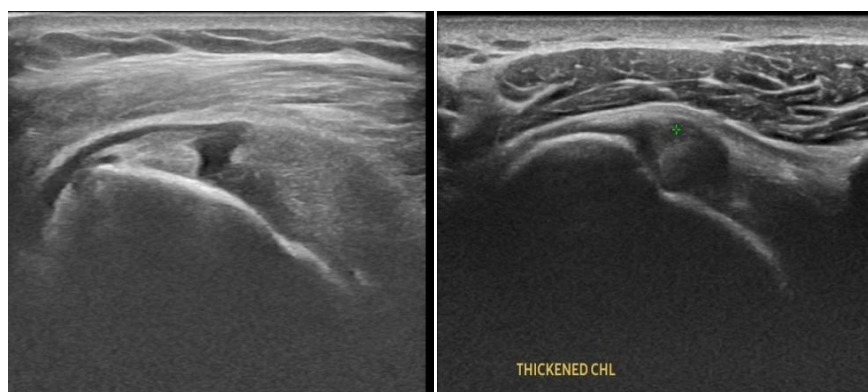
Ultrasound image showing full thickness tear of supraspinatus tendon. Image 2: Thickened coracohumeral ligament.
